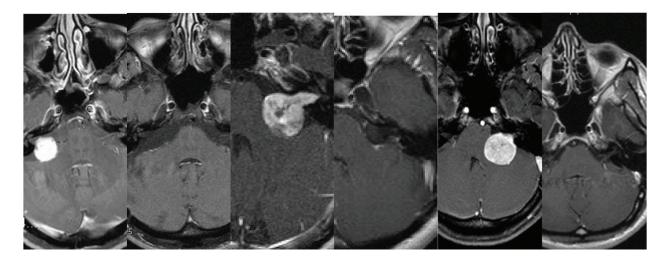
Axial MRI (T1-with contrast) of three operated cases (complete removal-retrosigmoid approach) with follow-up MRI after 31 months (case on the left side), after 29 months (case on the middle), and after 17 months (case on the right side) showing no tumor rest or recurrence.
